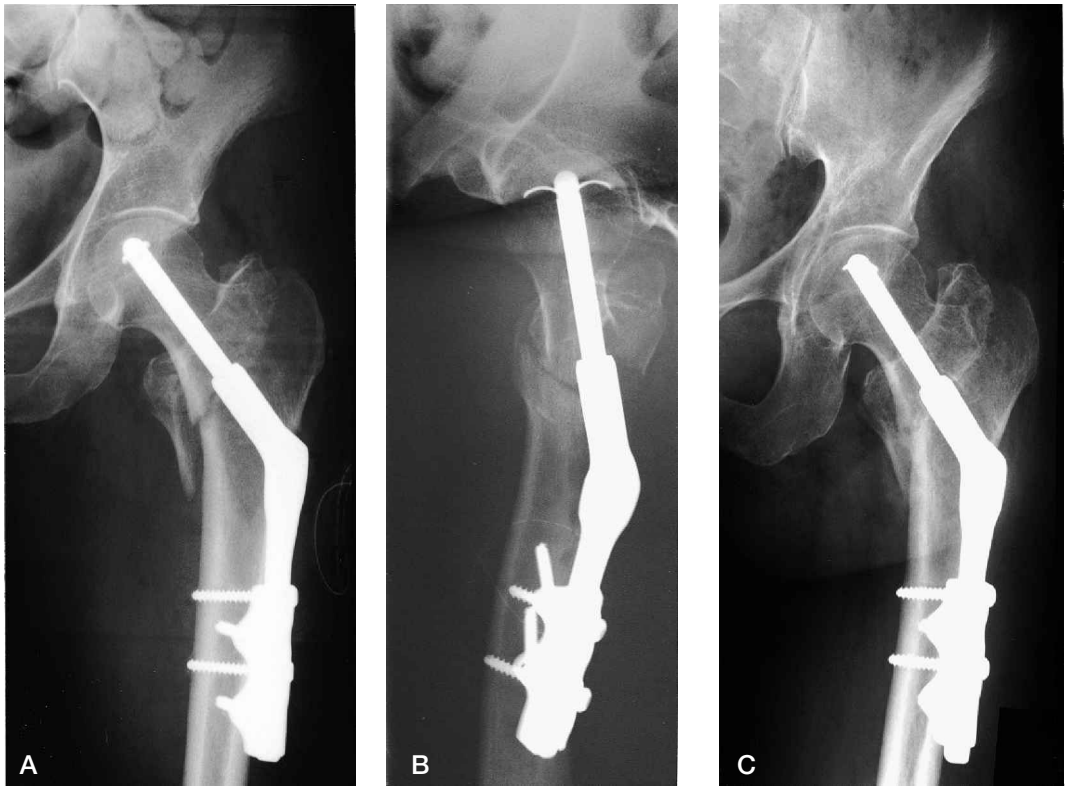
Radiographs postoperatively in the anterior (A) and lateral (B) views of an unstable intertrochanteric fracture (Jensen and Michaelsen type 5) treated with a 4-hole Medoff sliding plate and a Twin hook. No migration of the Twin hook occurred. The fracture was healed at the 4-month control (C).
